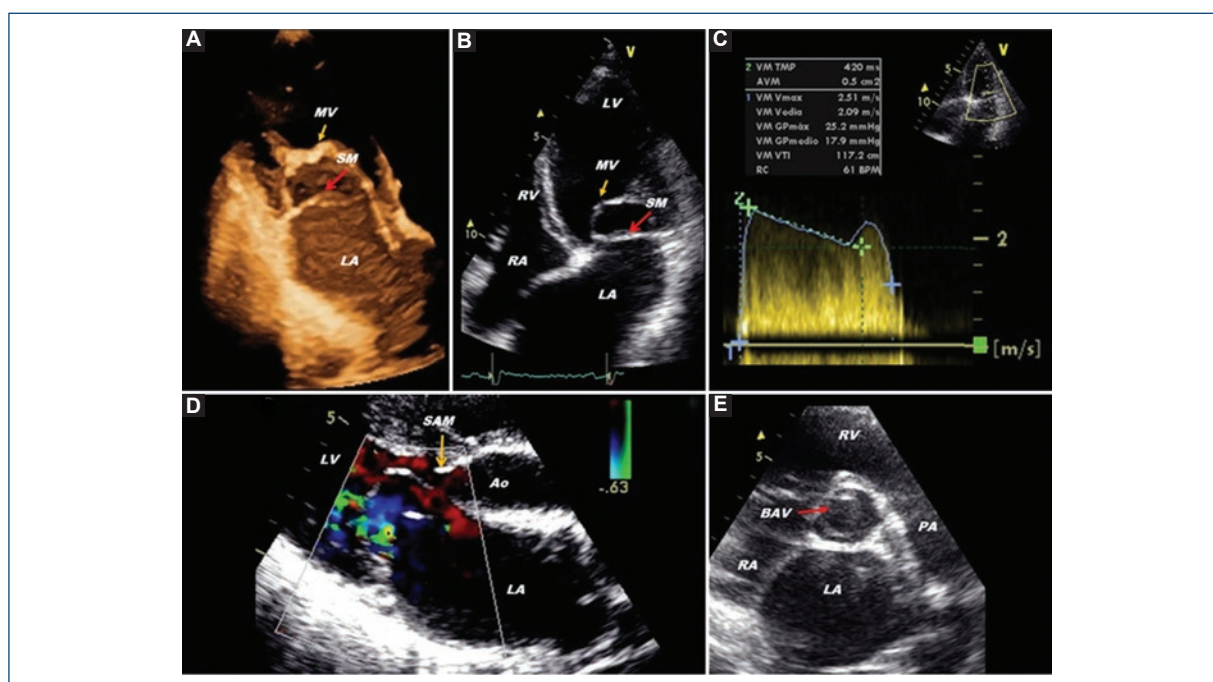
Transthoracic echocardiography. A: apical three-chamber view; B: apical four-chamber view; C: continuous Doppler, mitral valve gradient; D: parasternal long-axis color Doppler; E: parasternal short-axis view of aortic valve. BAV: bicuspid aortic valve; SM: supramitral membrane; MV: mitral valve; SAM: subaortic membrane; Ao: aorta; RA: right atrium; LA: left atrium; RV: right ventricle; LV: left ventricle; PA: pulmonary artery.
